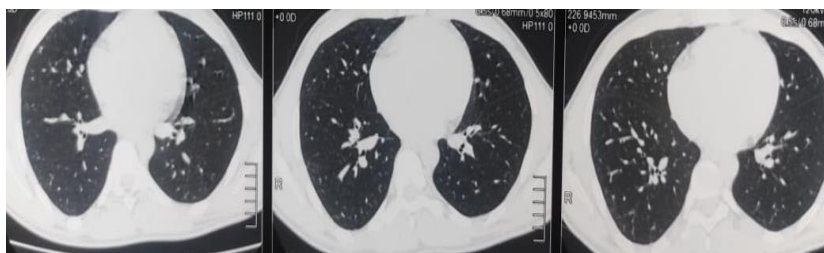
Radiological control (Computed Tomography Scan Thorax)
